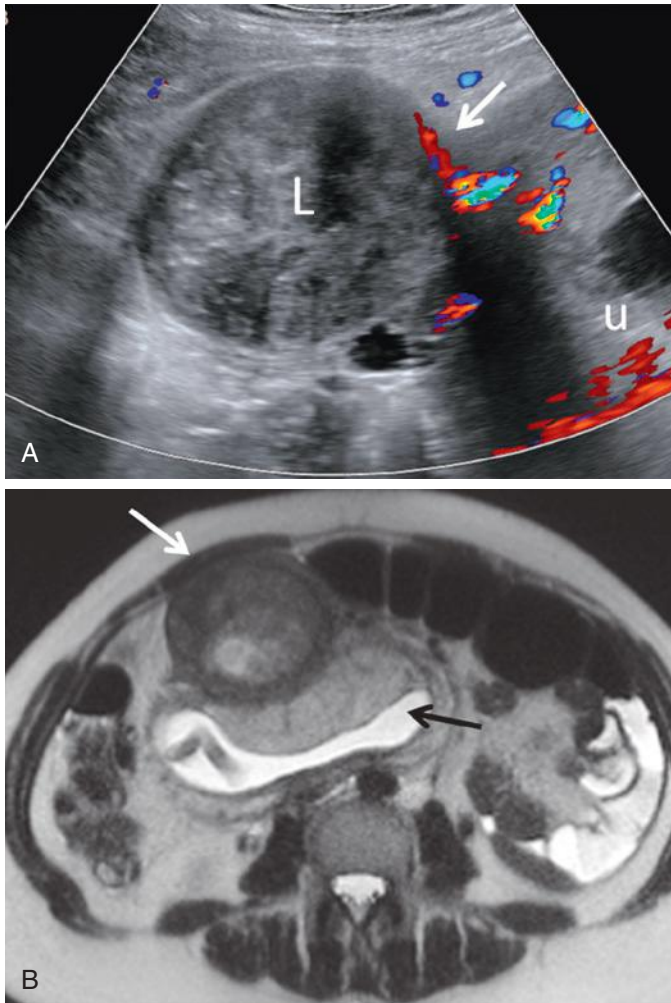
Degenerated exophytic leiomyoma in pregnant patient with right lower quadrant pain, initially evaluated for appendicitis. A, Trans-abdominal ultrasound image demonstrates an exophytic leiomyoma (L) with a bridging vascular sign (arrow) confirming origin from the gravid uterus (U). No flow is demonstrated in the leiomyoma owing to hemorrhagic degeneration. B, Magnetic resonance imaging was performed to assess for possible appendicitis. Axial T2-weighted image demonstrates heterogeneous, increased signal intensity in the leiomyoma (white arrow) owing to degeneration. The exophytic myoma is at the anterior aspect of the gravid uterus (black arrow).
